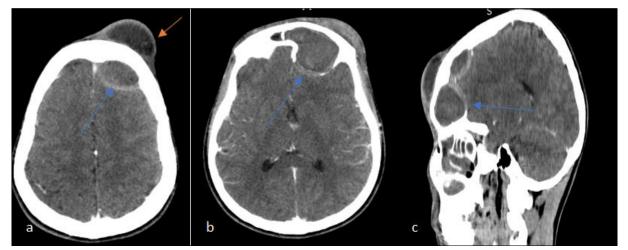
Head CT scan, axial (a) without contrast, axial (b) and sagittal (c) with contrast, showing a frontal mucocele (orange arrow) with destructive involvement of the posterior wall of the frontal sinus, causing a scalloping effect on the anterior wall. The mucocele was complicated by a cerebral empyema (blue arrow) and a left-sided subcutaneous frontal collection, which communicated with the mucocele through a petrous channel
